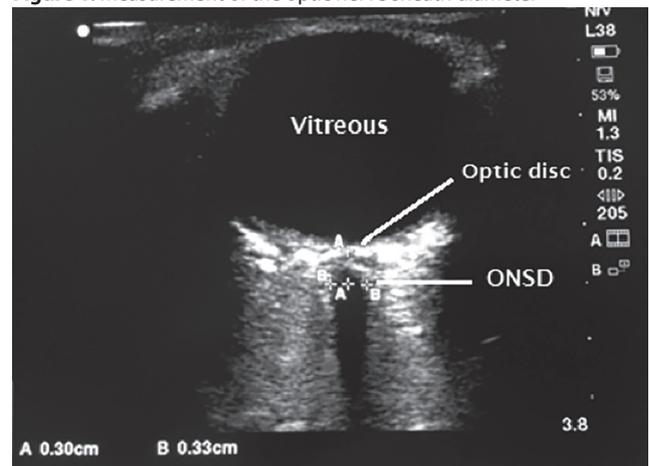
Ultrasonographic image of the eye and optic nerve system –B =3.3 mm; ONSD = Optic nerve sheath diameter. Measurements are taken 3 mm behind the globe of the eye. This patient had an intracranial pressure of 11 mmHg
